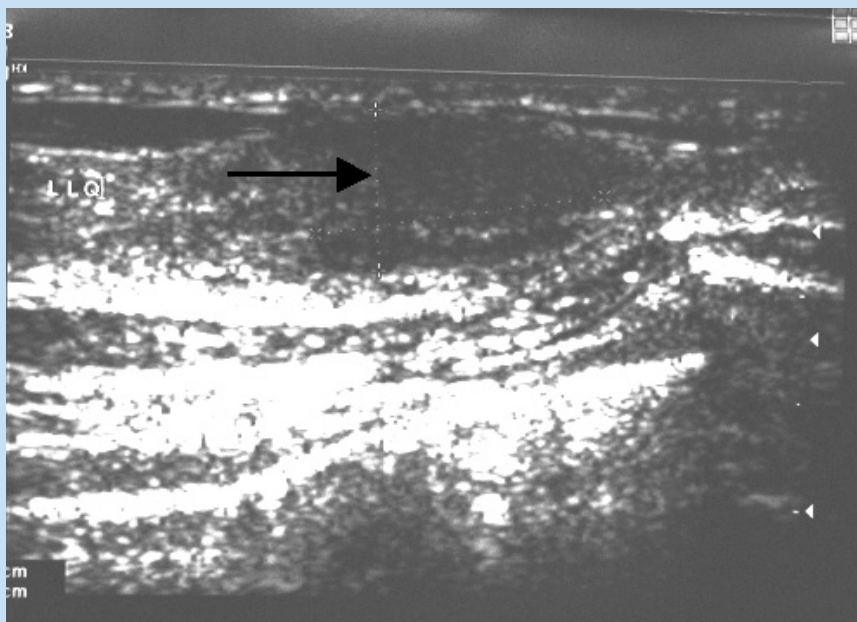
Ultrasound of the left breast demonstrates an ill-defined irregular hyperechoic lesion suggesting malignancy (arrow).
